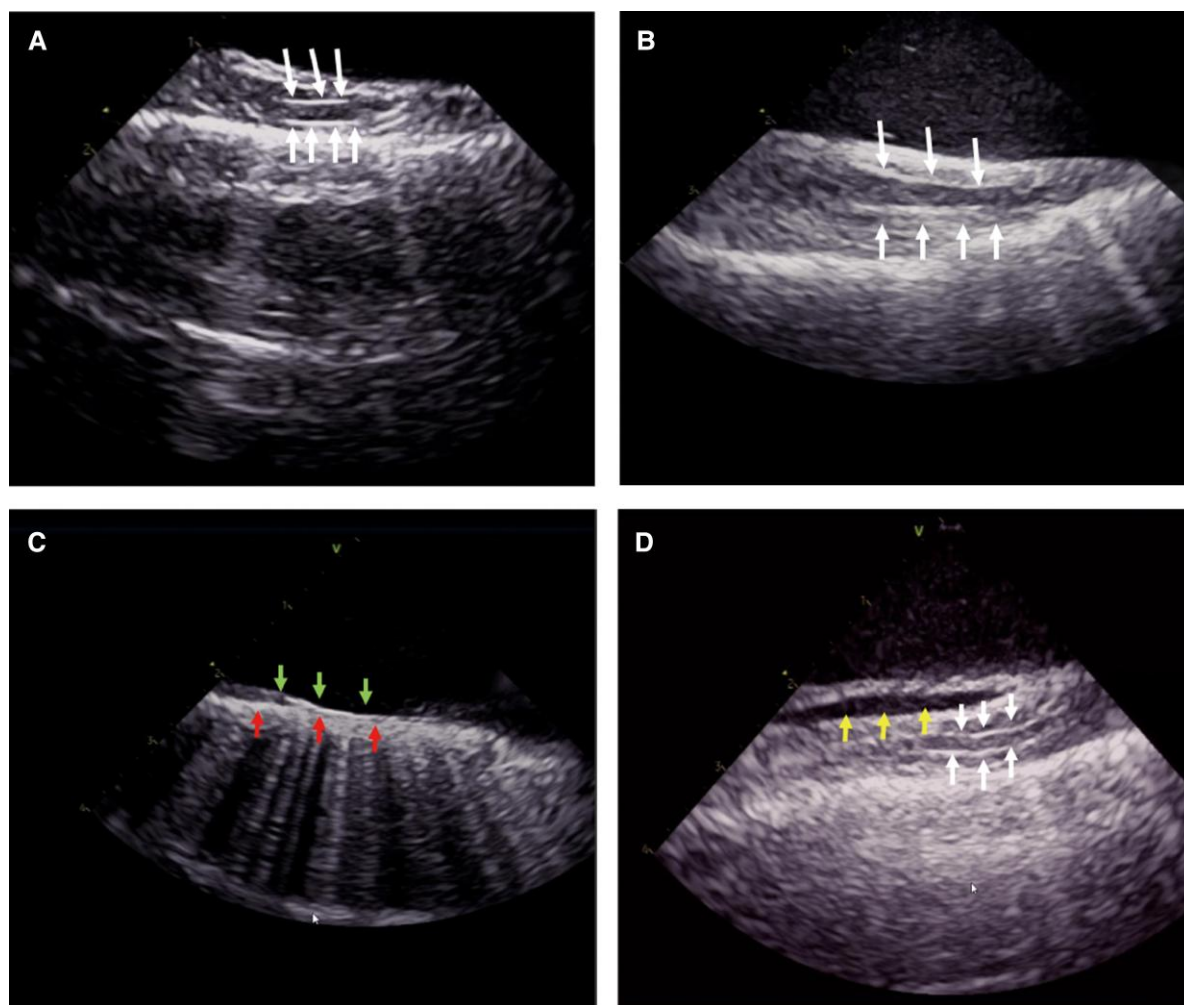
The intracardiac echocardiography (ICE) image of the right phrenic nerve (RPN). The RPN is a round, thin structure with a ‘straw’-like appearance, that is centrally hypoechoic and peripherally hyperechoic between the superior vena cava (SVC) and the mediastinal pleura. The arrow indicates the RPN (Figure 2A–B). Bottom row of arrows indicate the mediastinal pleura and up row of arrows indicate the intima of SVC, the RPN could not be identified due to a narrowed space between the SVC and the mediastinal pleura (<1 mm) (Figure 2C). Arrows on left indicate reflexed pericardium and arrows on right indicate the RPN; the fluid separates the visceral pericardium from the parietal pericardium in the inferior part of the SVC (Figure 2D).
